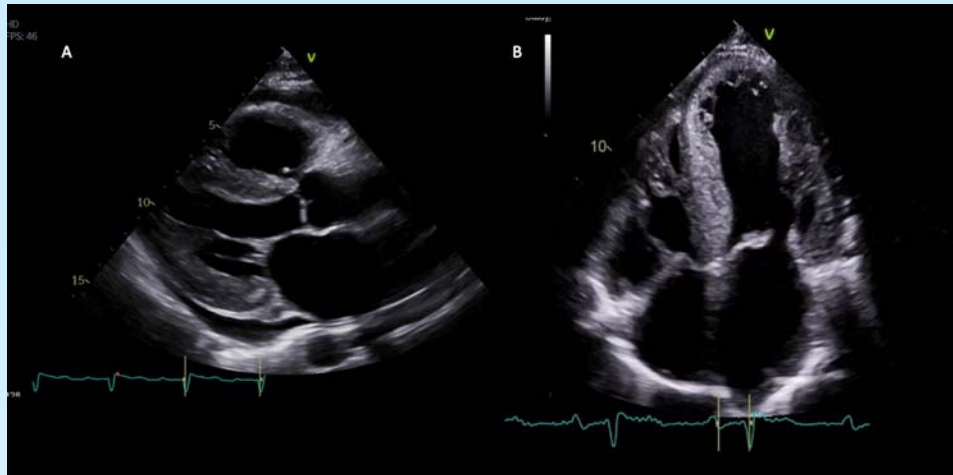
Typical echocardiographic findings. (A) Parasternal long-axis view: the ventricular wall thickness is increased, there is atrial dilation, and a small pericardial effusion is seen. (B) Apical 4-chamber view. Increased biventricular wall thickness, biatrial dilation, and valvular thickening are shown.
